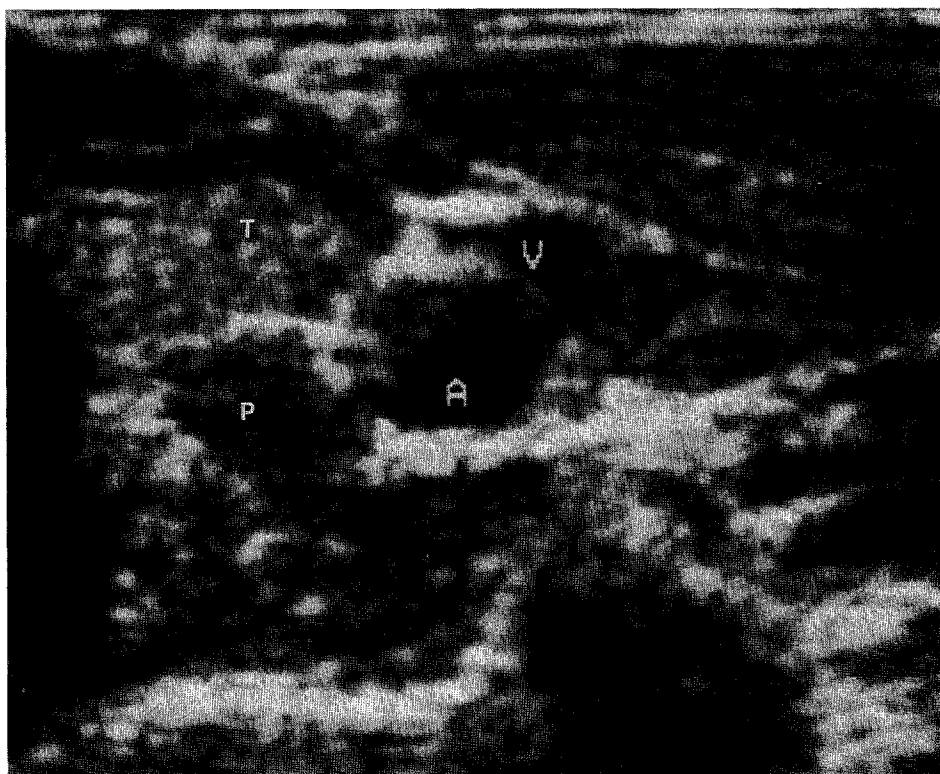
Ultrasound of the neck showing a small parathyroid adenoma in the axial plane, posterior to the superior portion of the left lobe of the thyroid gland and medial to the carotid artery. V, jugular vein; A, carotid artery; T, left lobe of thyroid gland; P, parathyroid adenoma.
